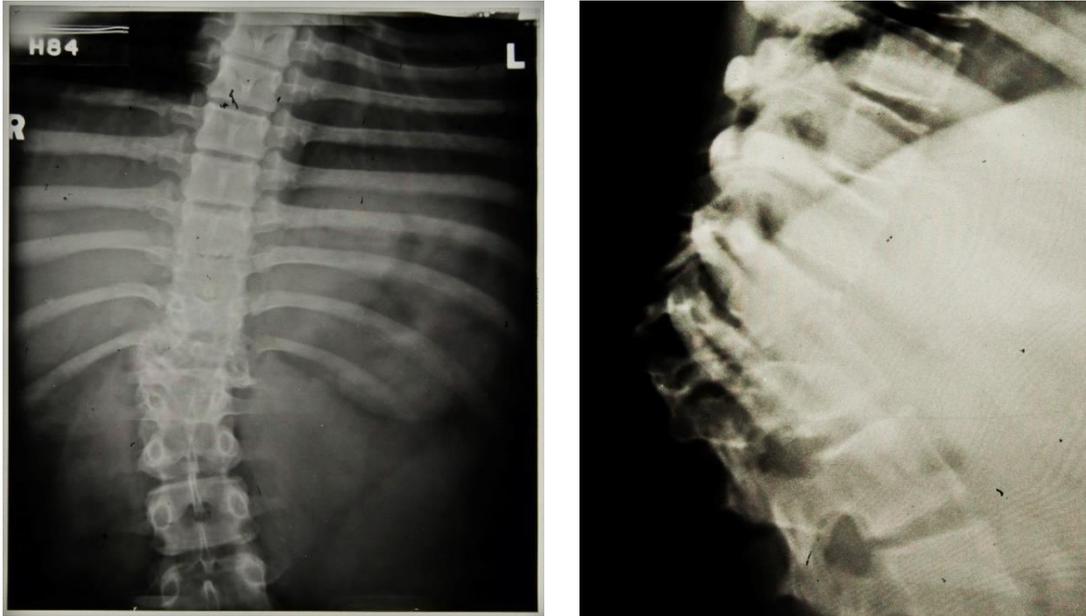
Patient 87/62 Radiograph report 10th July 1939: 'Abscess shadow showing T11-L1. Not healed'. The image on the right required much contrast adjustment to improve the visibility of the lesion. (HOSP/STAN/7/1/2/487_06 & 09)
